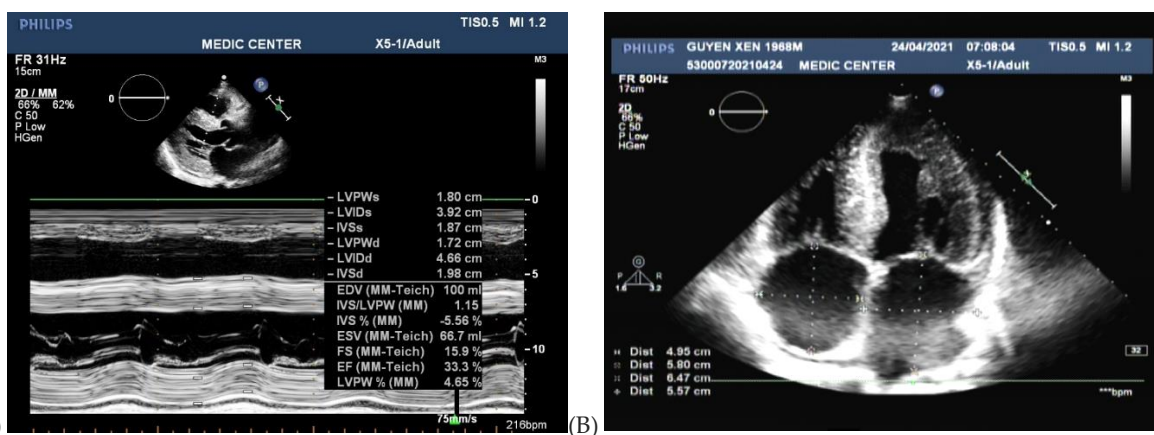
A: Parasternal LAX view demonstrated the thickening of LV walls (IVSd=20mm, PWd=17mm) with marked reduce of LV. B: Apical 4 C view showed LV hypertrophy with the sparkling sign of myocardium, biatrial enlargement and thickening of IAS.
